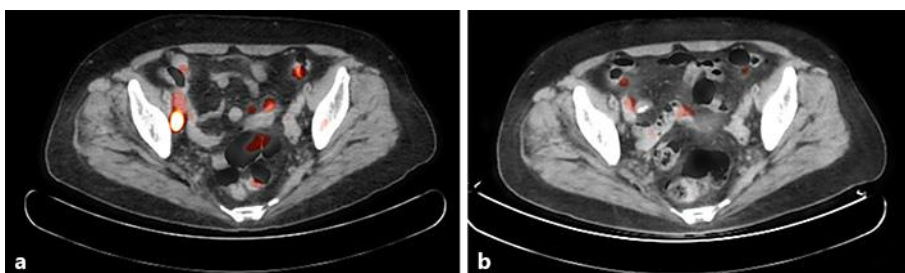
Prior to the treatment of the patient with nivolumab, the fluorodeoxyglucose positron emission tomography (FDG-PET) scans showed a high level of uptake in the right pelvic lymph node (a). After the patient had been treated with 6 courses of nivolumab, the FDG-PET scans showed a decrease in uptake in the right pelvic lymph node (b).
